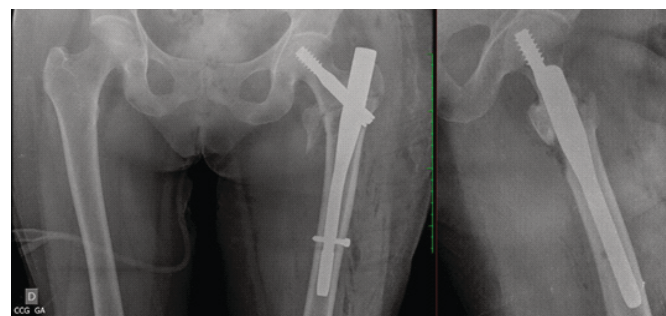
Postoperative radiographs showing fracture reduction and fixation.
